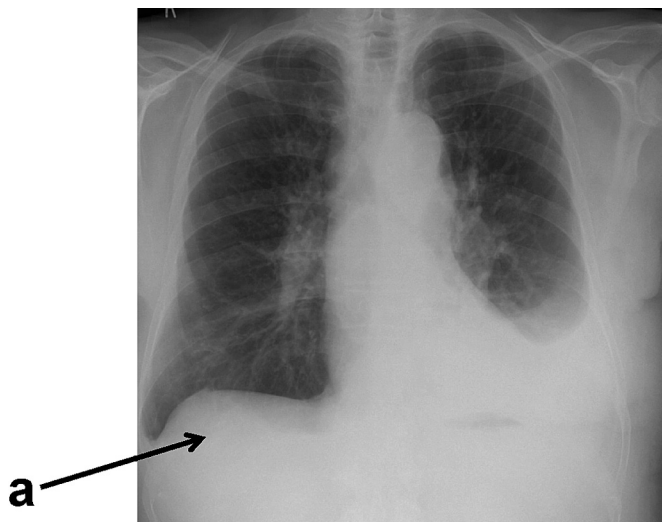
Chest x-ray showing a moderate left pleural effusion and subpulmonic effusion on the right (a). Note the lateral peaking of the right hemidiaphragm. Reproduced with permission from Professor David Milne, Auckland University.
